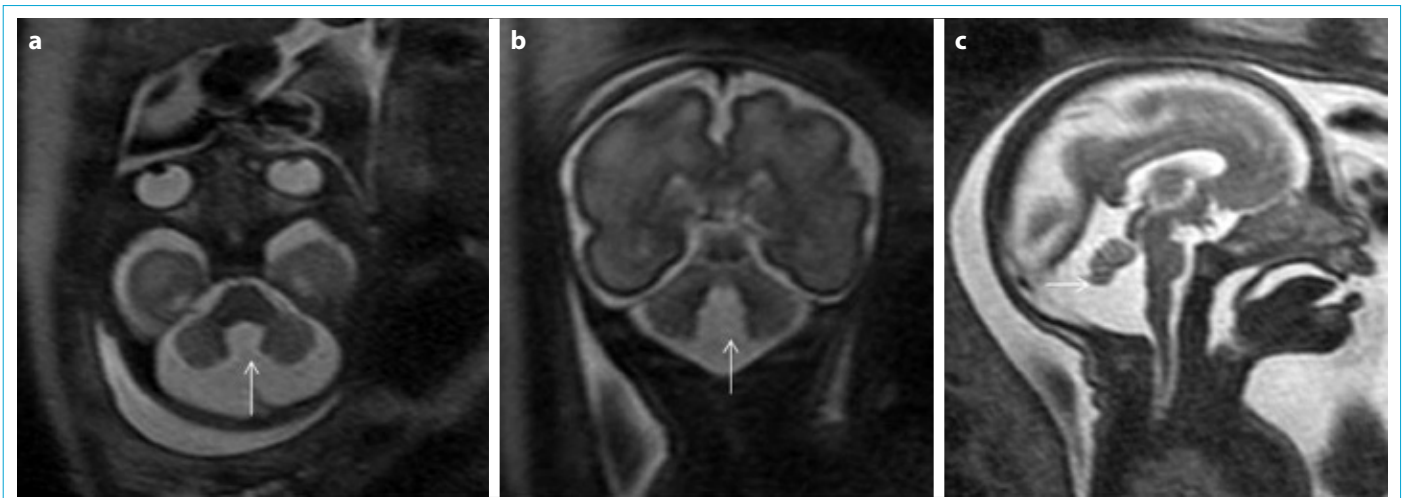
(a-c). Axial (a), coronal (b), and sagittal (c) T2-weighted MRI show parsiel vermis hypoplasia (arrow).
